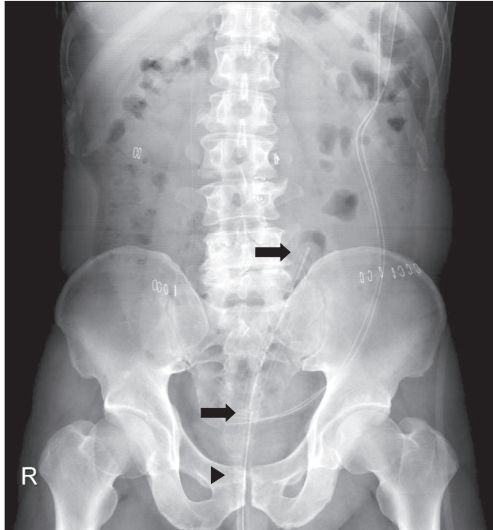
Plain x-ray shows the transanal tube (TAT) remaining in the intraluminal space after installation. Main drainage portion of the TAT can be seen between the arrows. Arrowhead is indicating stapler line of anastomosis.
